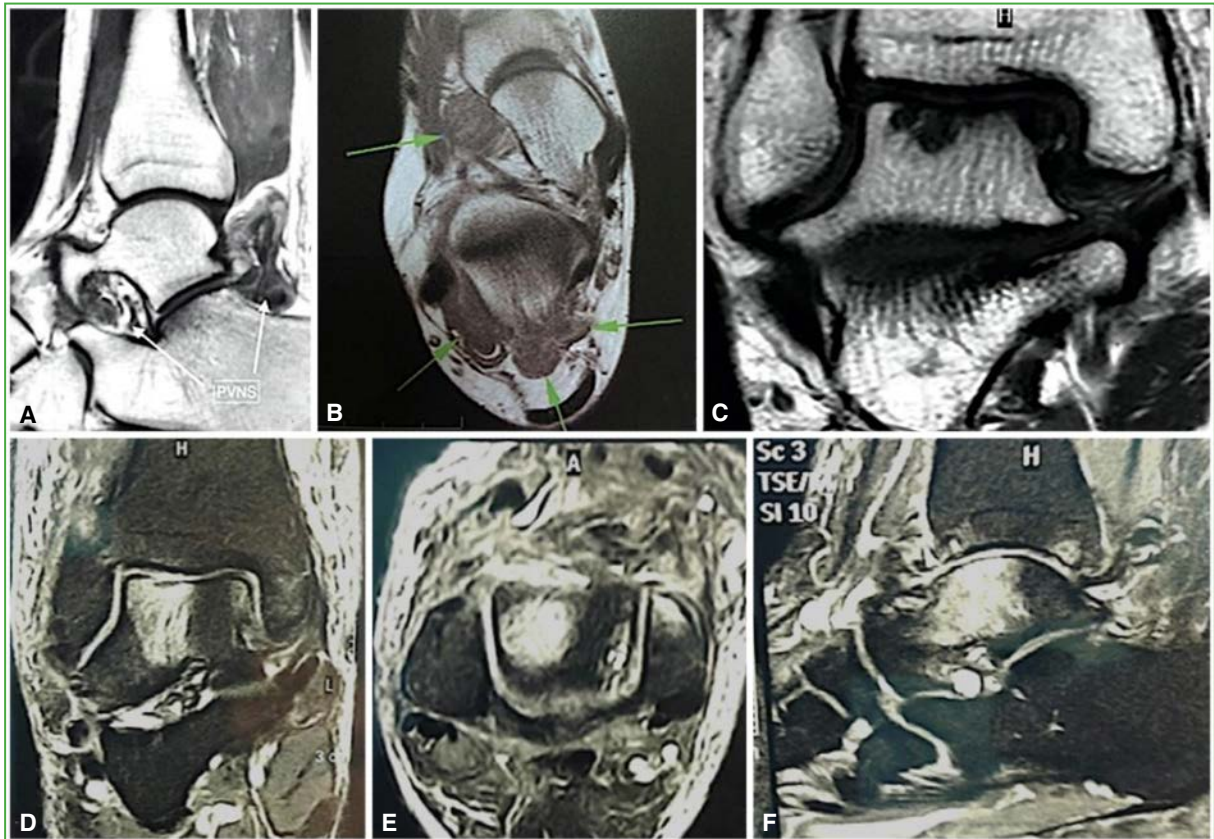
Magnetic resonance imaging of the ankle and hindfoot. The lesions are typically hypointense on both T1- and T2-weighted sequences because of the paramagnetic properties of hemosiderin. A. Sagittal T1-weighted image of the subtalar joint. Note the hypointense appearance of a tenosynovial giant cell tumor in the sinus tarsi and the posterior facet (white arrows). B. Axial image. Green arrows indicate the hypointense lesions of a tenosynovial giant cell tumor. C. Coronal image. Articular involvement of the talar cartilage and bone marrow. D. Coronal T2-weighted image of a tenosynovial giant cell tumor. E. Axial image. Extensive bone marrow edema involving the articular cartilage of the talar dome. F. Sagittal image. Kissing lesions involving the talar dome and the tibial plafond.
